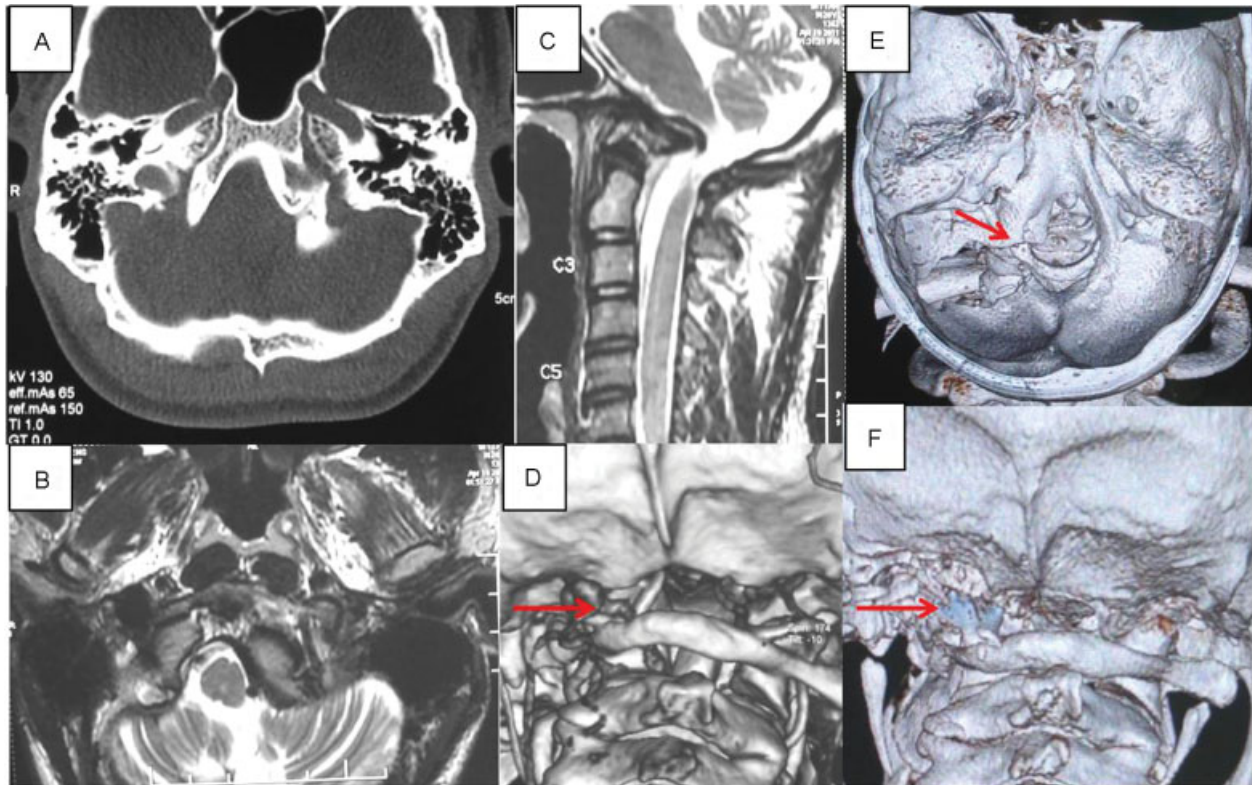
Preoperative: (A) Axial section computed tomography (CT) image with bone window setting at the level of occipital condyles (OCs) showing malunited fracture of left OC seen as a bony exuberance projecting posteromedially with resultant asymmetry. (B) T2-weighted axial magnetic resonance (MR) image at the level of skull base reveals posteromedially dislocated left lateral mass of C1 causing rotational compression of cervicomedullary junction (CMJ) and effacement of adjacent cerebrospinal fluid space. (C) Left parasagittal T2-weighted MR image shows prominent anterior bony projection causing compression of CMJ. (D) Volume-rendered CT image of CVJ viewed from posterior aspect reveals translational and rotatory dislocation of atlanto-occipital joint (AOJ) with reduced AOJ space (arrow) on the left side. Postoperative: (E) volume-rendered CT image of foramen magnum and CVJ (posterosuperior view) shows partially excised left OC (arrow) with adjoining left paramedian suboccipital craniectomy. (F) Volume-rendered CT image of foramen magnum and CVJ (posterior view) shows titanium cage (arrow) used for distraction of left AOJ space.
